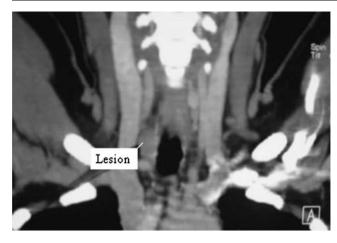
CT scan on Coronal section shows a small globular lesion along the right posterolateral aspect of the trachea closely related to upper portion of esophagus
